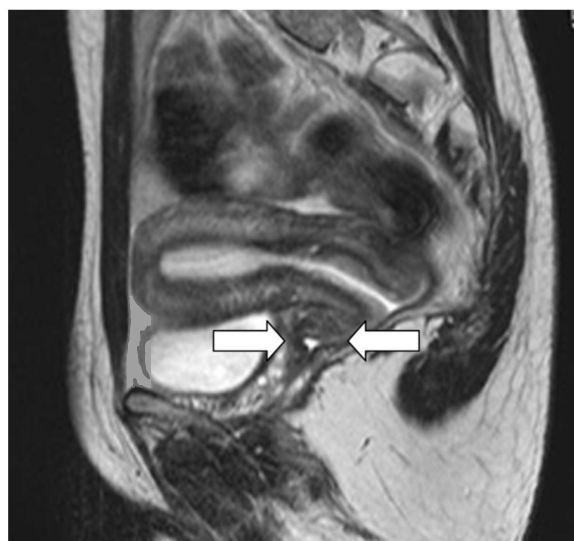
Magnetic resonance imaging findings of the patient. Magnetic resonance imaging revealed the presence of a divided vaginal space and a normal-sized uterus and ovaries (arrows).
